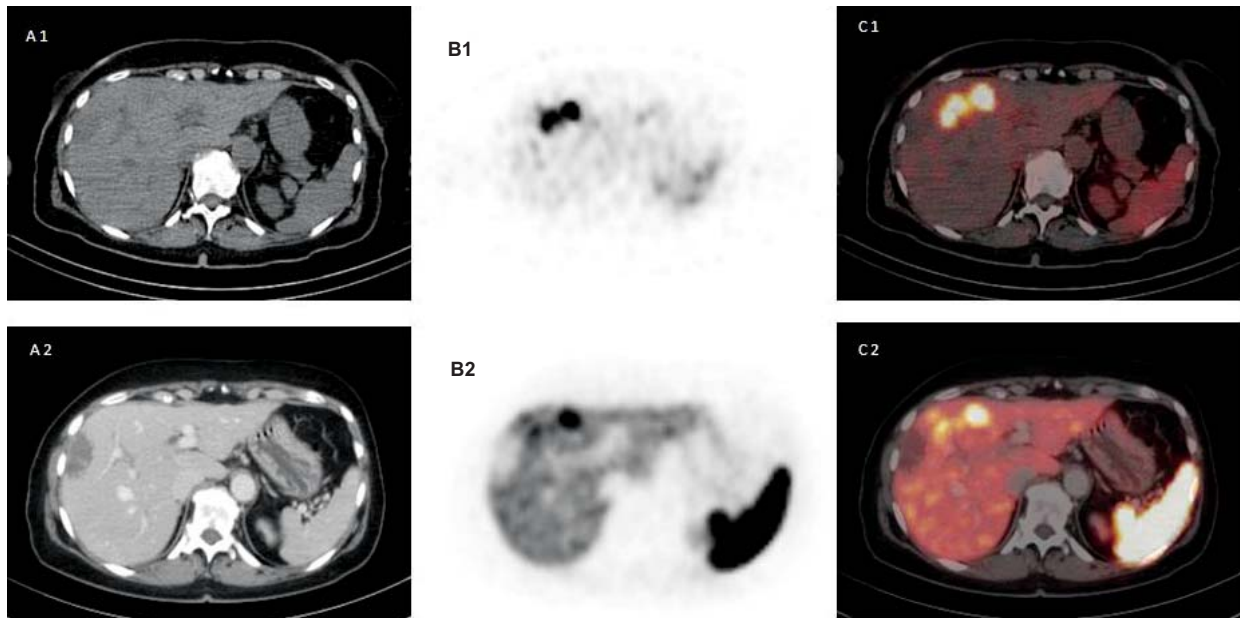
5 years old patient with somatostatin receptor positive gastrointestinal neuroendocrine tumour and hepatic metastases referred for Lutetium-177-DOTATATE therapy (radioreceptor nuclide therapy) and [ $^{68}\text{Ga}$ ]DOTATOC PET/CT for re-staging after therapy. (A1) CT, (B1) SPECT, (C1) SPECT/CT fused images after Lu-177-DOTATATE; (A2) CT, (B2) PET, (C2) PET/CT fused images for restaging 6 weeks after Lu-177-DOTATATE therapy showing good therapy response.
